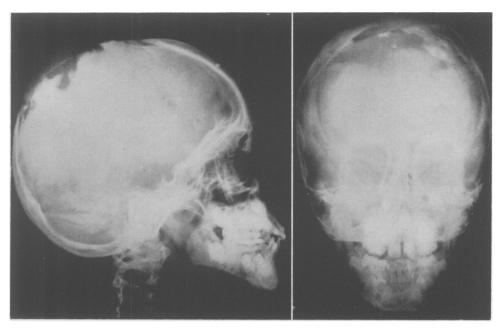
Case 3. X-ray of the skull, showing bony defects.
